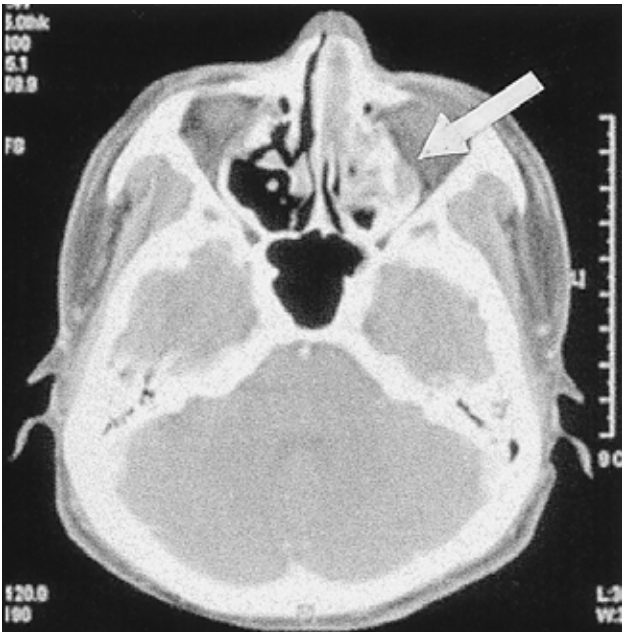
Computed tomography of the paranasal sinus showing a soft tissue density mass in the left middle meatus and associated obstructive sinusitis in the left maxillary sinus.
